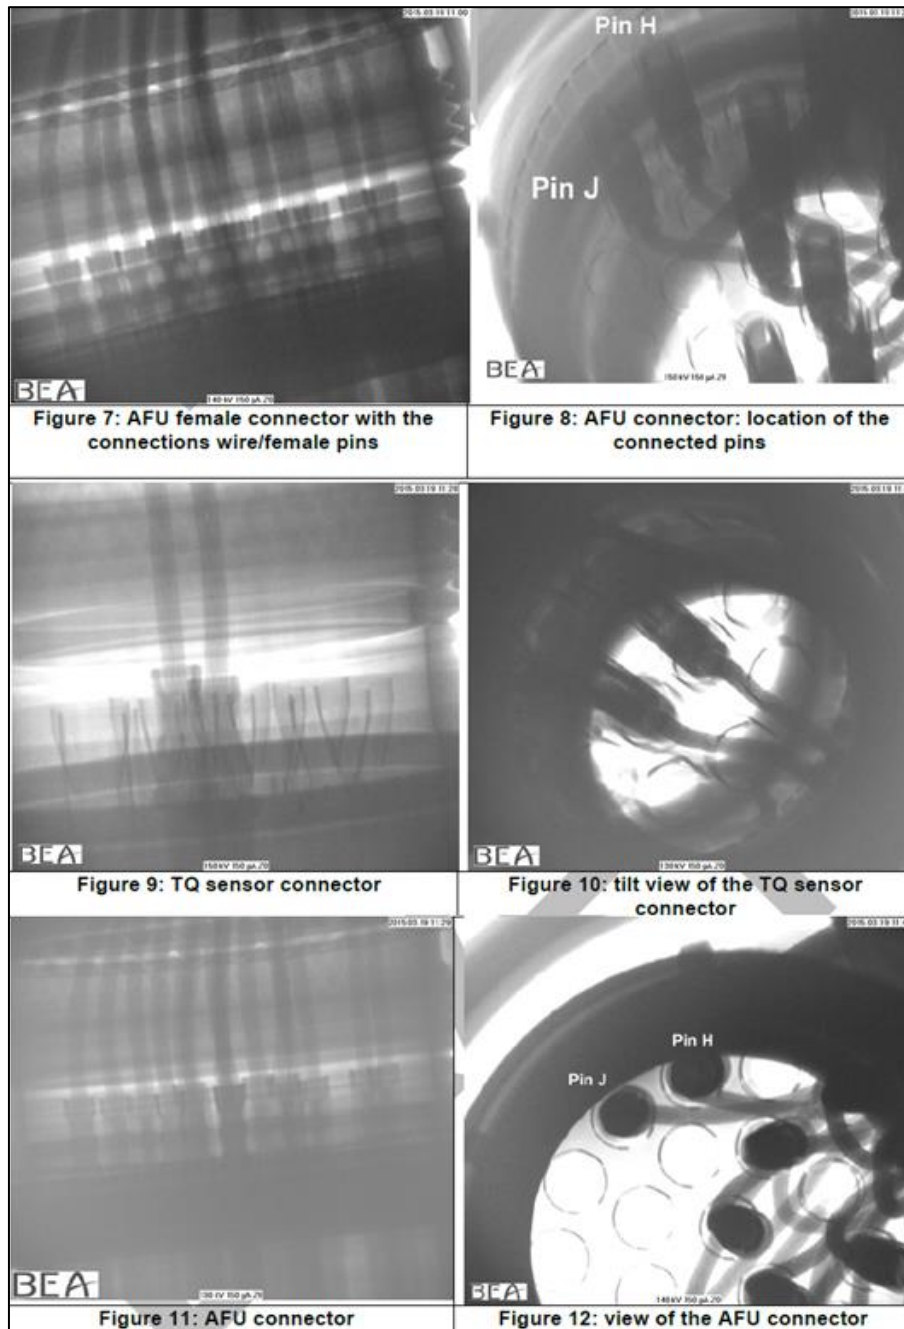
X-ray examination of AFU and torque sensor connectors
